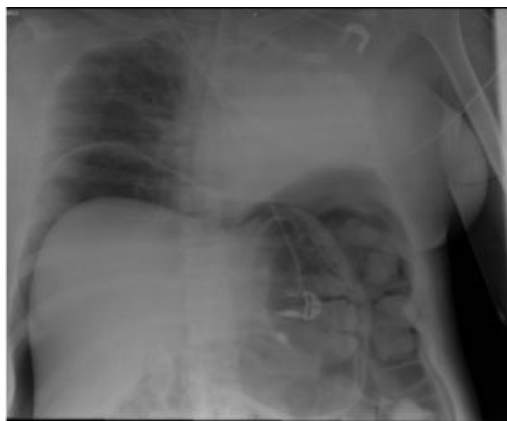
Chest and abdominal x-ray in the supine position, showing a left pulmonary atelectasis and free gas under diaphragmatic cupule.
